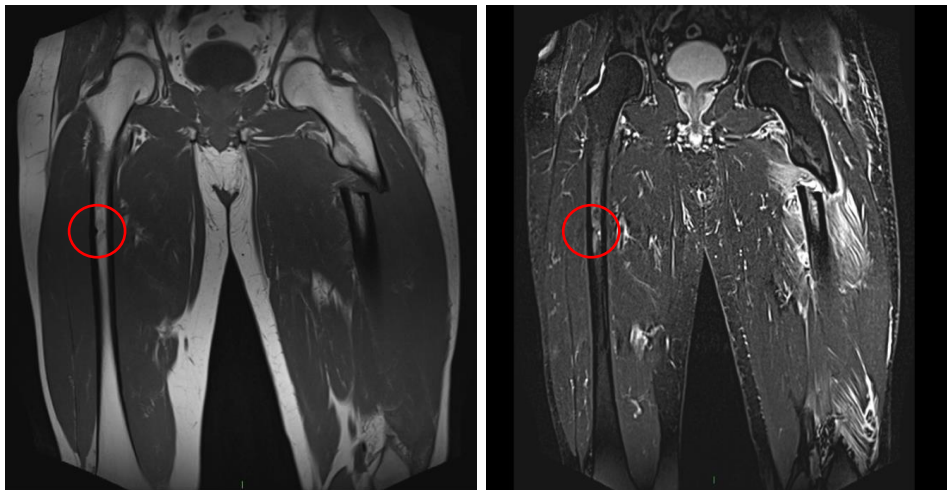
Magnetic resonance Imaging identifying contralateral iAFF of the right femur following index fracture of the left femoral shaft.
